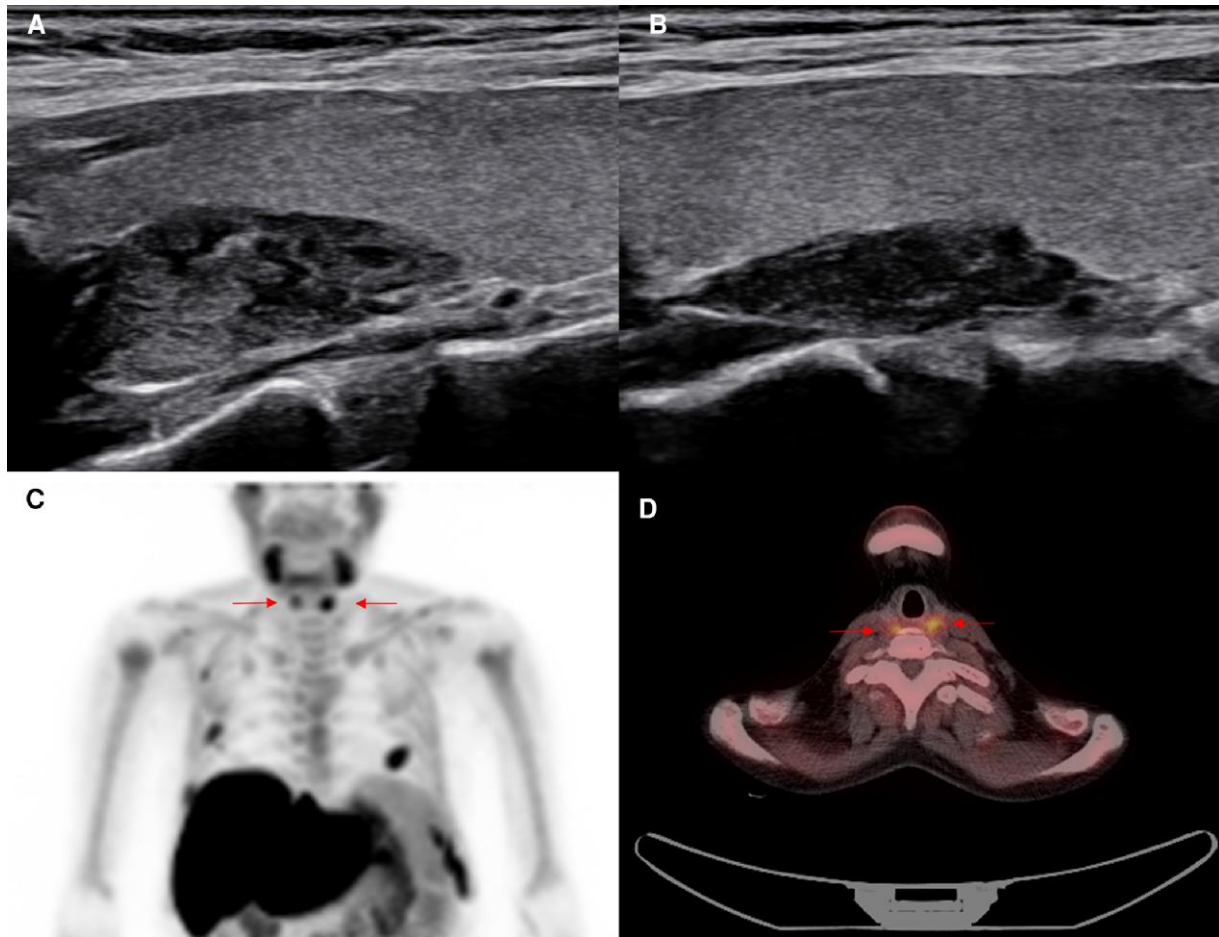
Imaging of parathyroid nodules. (A, B) Neck ultrasonography showing hypoechoic nodules at the upper poles of the left and right thyroid lobes. (C) ^{18}F -fluorocholine positron emission tomography (PET)/CT (maximum intensity projection) demonstrating increased radiotracer uptake in extrathyroidal nodules at both upper poles (arrows). (D) Axial fused PET/CT image confirming focal radiotracer uptake in an extrathyroidal nodule (arrows).
